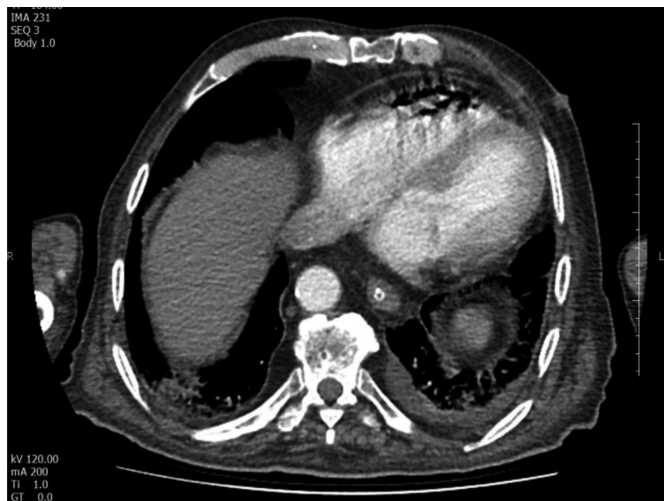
Contrast-enhanced axial CT scan of chest. Air is seen in the heart.
